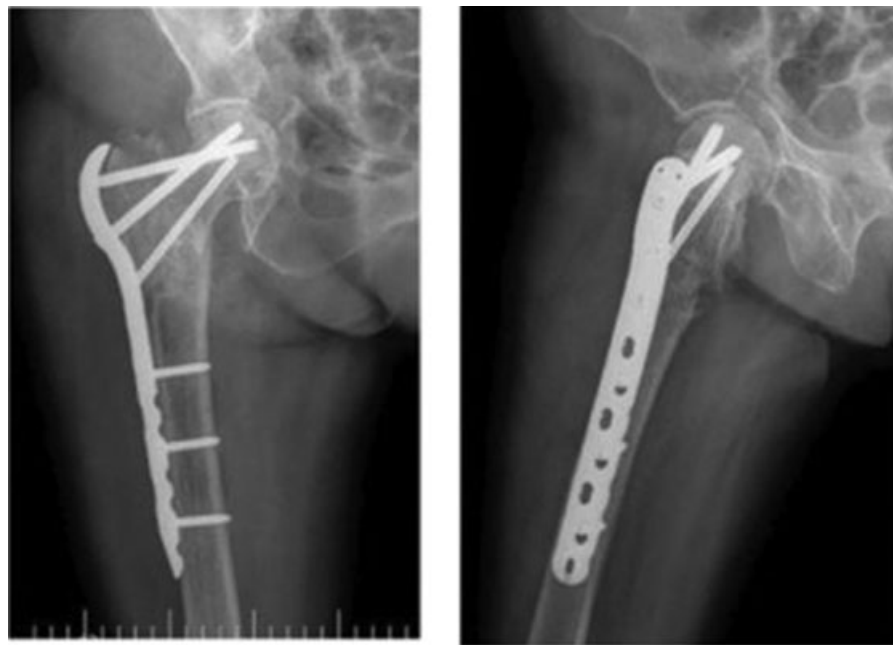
Right hip AP and profile radiographs after definitive treatment.
